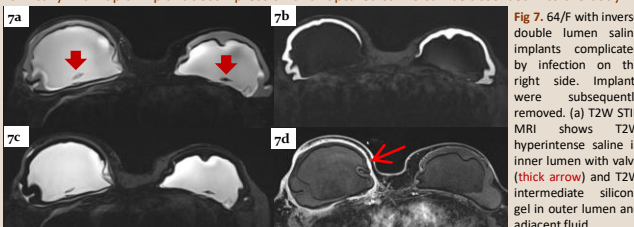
64/F with inverse double lumen saline implants complicated by infection on the right side. Implants were subsequently removed. (a) T2W STIR MRI shows T2W hyperintense saline in inner lumen with valve (thick arrow) and T2W intermediate silicone gel in outer lumen and adjacent fluid. (b) T2W STIR water suppression shows that inner lumen saline is suppressed while the outer lumen silicone is hyperintense. (c) T2W STIR silicone suppression suppresses the outer lumen silicone. (d) T1W post contrast shows increased circumferential capsular enhancement around right breast implant (thin arrow), suggestive of infection.
